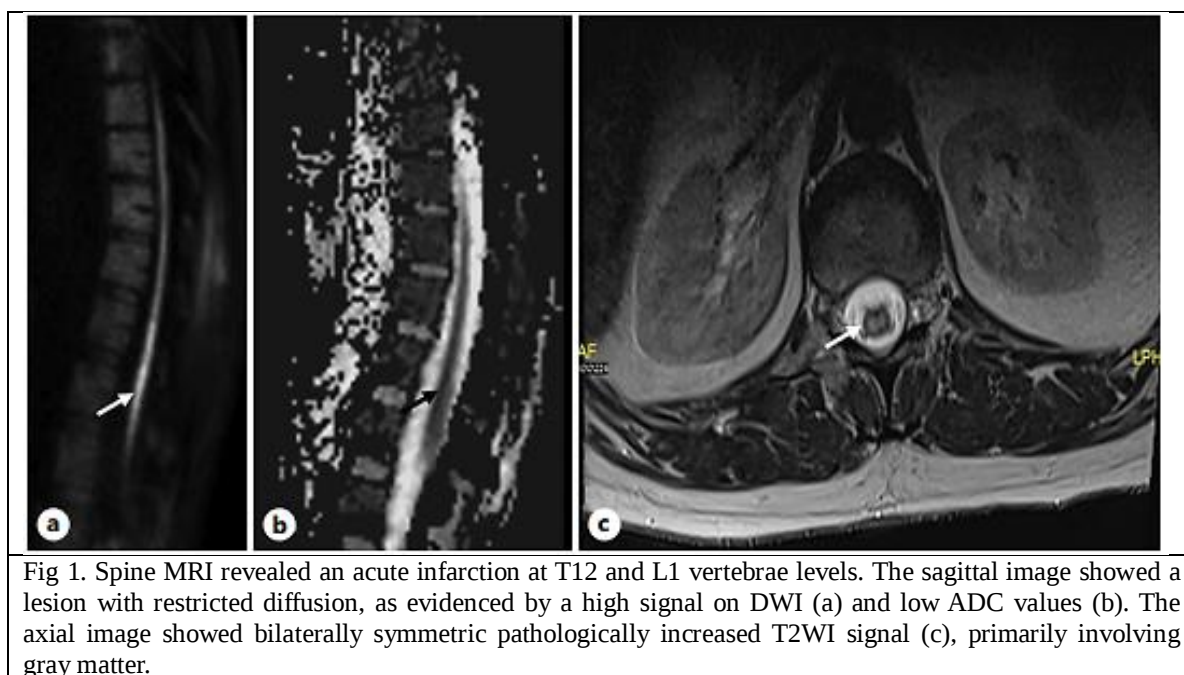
Spine MRI revealed an acute infarction at T12 and L1 vertebrae levels. The sagittal image showed a lesion with restricted diffusion, as evidenced by a high signal on DWI (a) and low ADC values (b). The axial image showed bilaterally symmetric pathologically increased T2WI signal (c), primarily involving gray matter.
